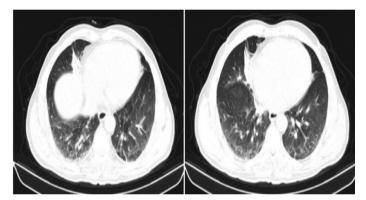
Chest computed tomography scan (without contrast) performed on the 16th hour of ingestion: Consolidation are as containing air bronchograms secondary to parenchymal infiltration can be seen in the anterobasal segment of inferior lobe of the right lung
